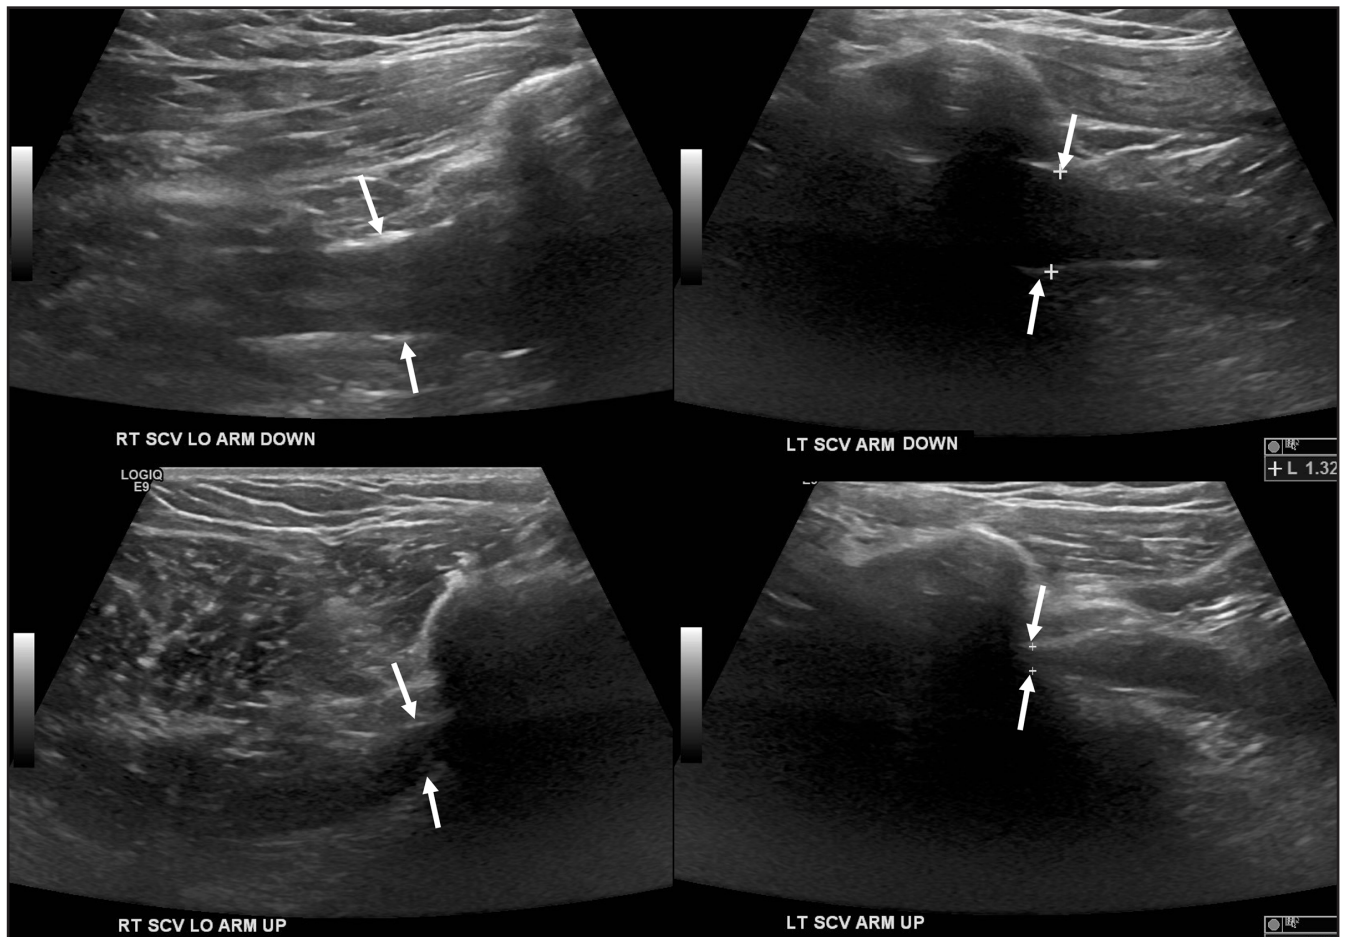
A 30-year-old man with mild neurogenic symptoms (numbness and tingling without weakness) during overhead activities. B-mode ultrasound was performed for suspected bilateral thoracic outlet syndrome with arms up and down as indicated. Dynamic imaging demonstrates narrowing of the subclavian veins upon arm raising at the costoclavicular spaces. These changes are more apparent on the left-side (solid white arrows highlight the caliber of the subclavian veins). This patient did not want to proceed with MRI, which would allow better evaluation of any neural compression or underlying compressive lesion.
